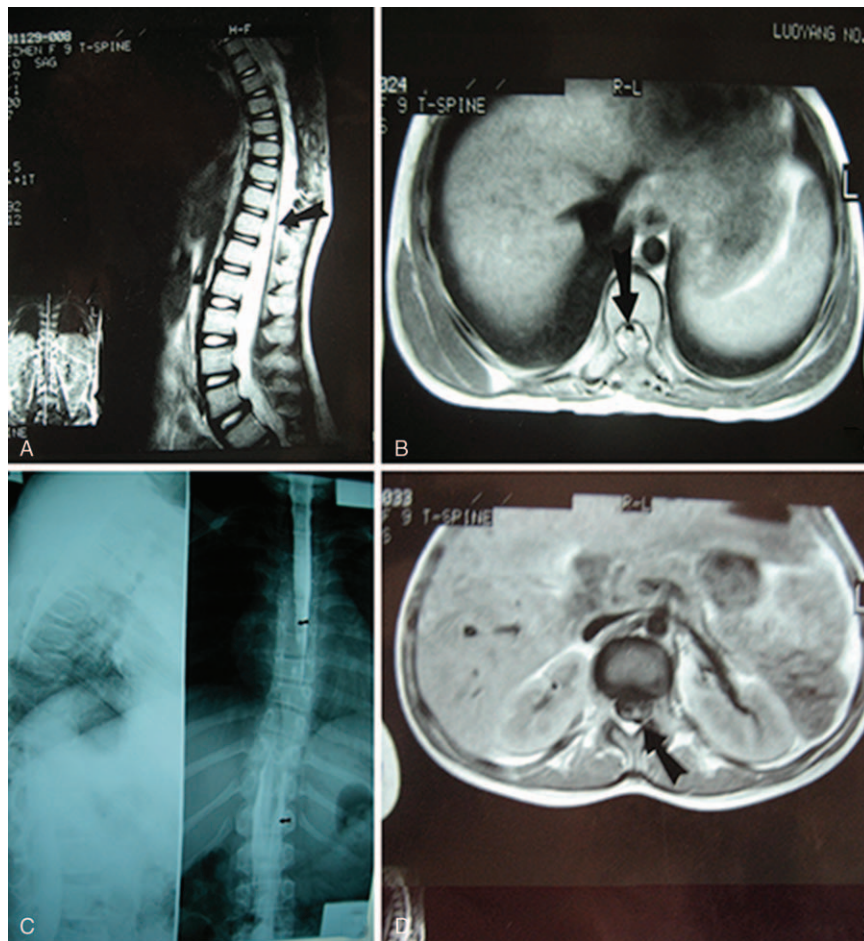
(A) Epidural spindle-like adipose tissue deposition and an abnormal fibrous strip were revealed by the sagittal-plane MRI. (B, C) The abnormal fibrous strip was revealed by the frontal-plane MRI. (D) Intraspinal filling defect displayed by the preoperative x-ray film; the dural sac and spinal cord were pushed away.
